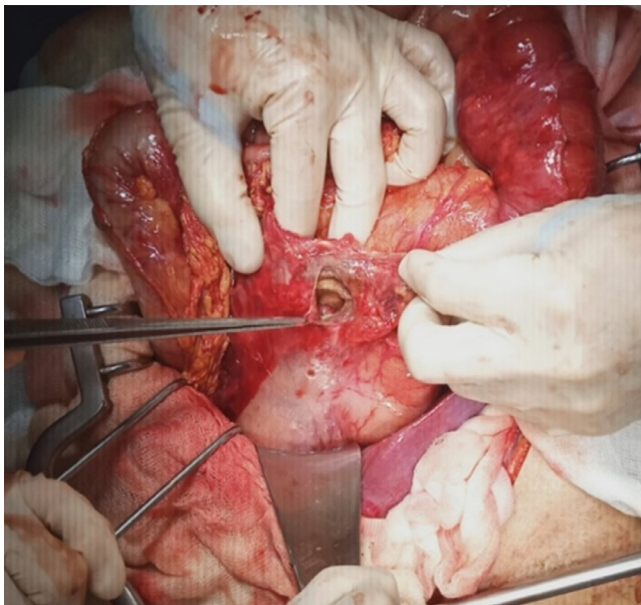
Intraoperative findings. A 4-cm hole in the greater curvature of the stomach was identified during the laparotomy, which was consistent with the CT findings.
